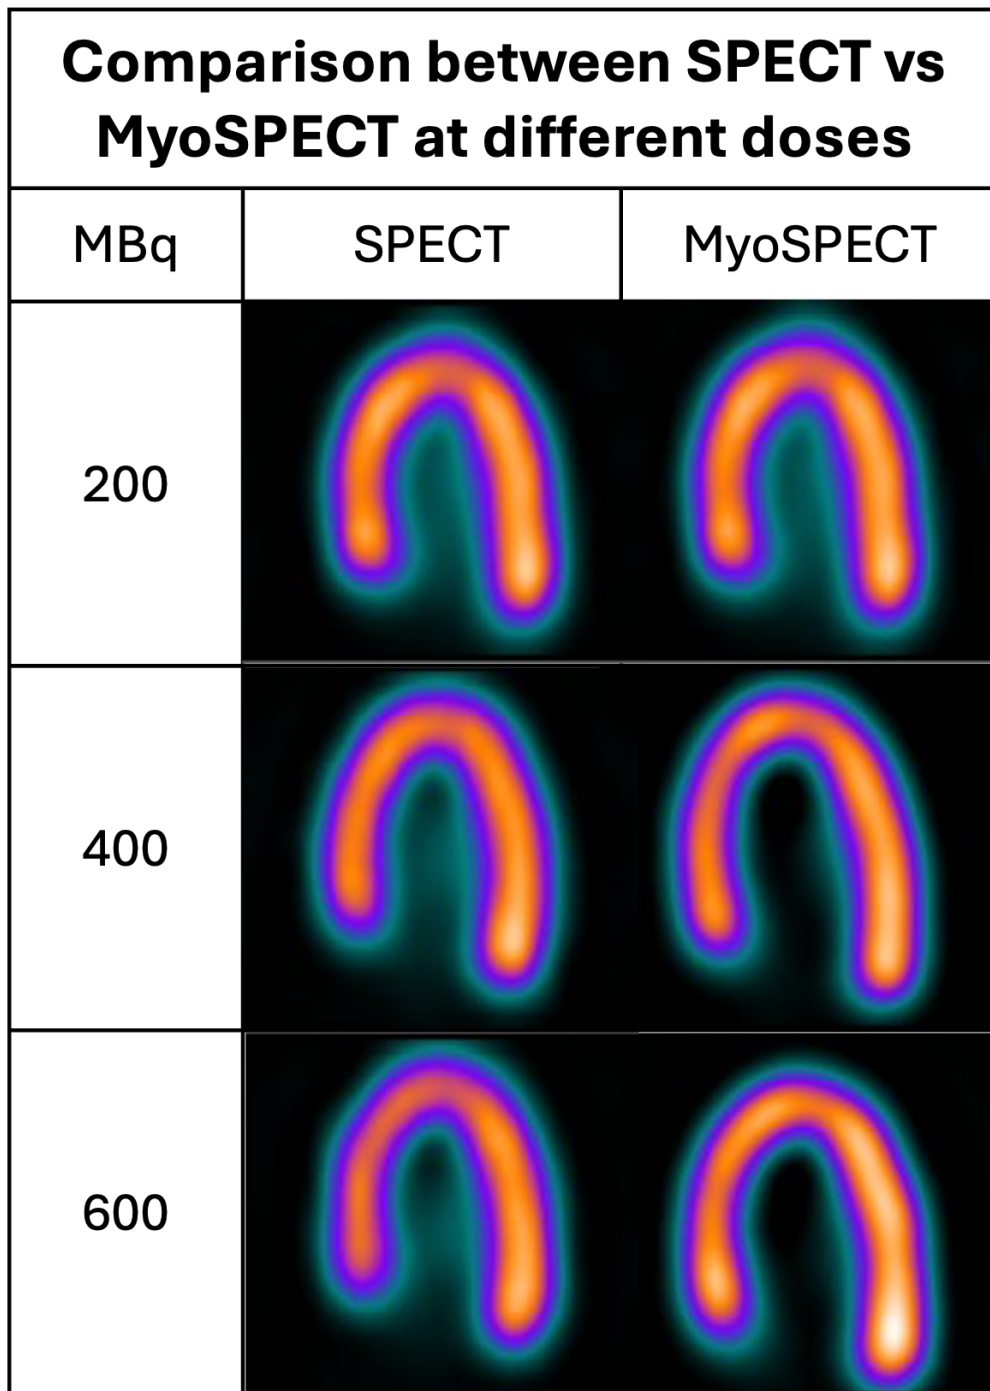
Comparison of SPECT and MyoSPECT through the HLA view
